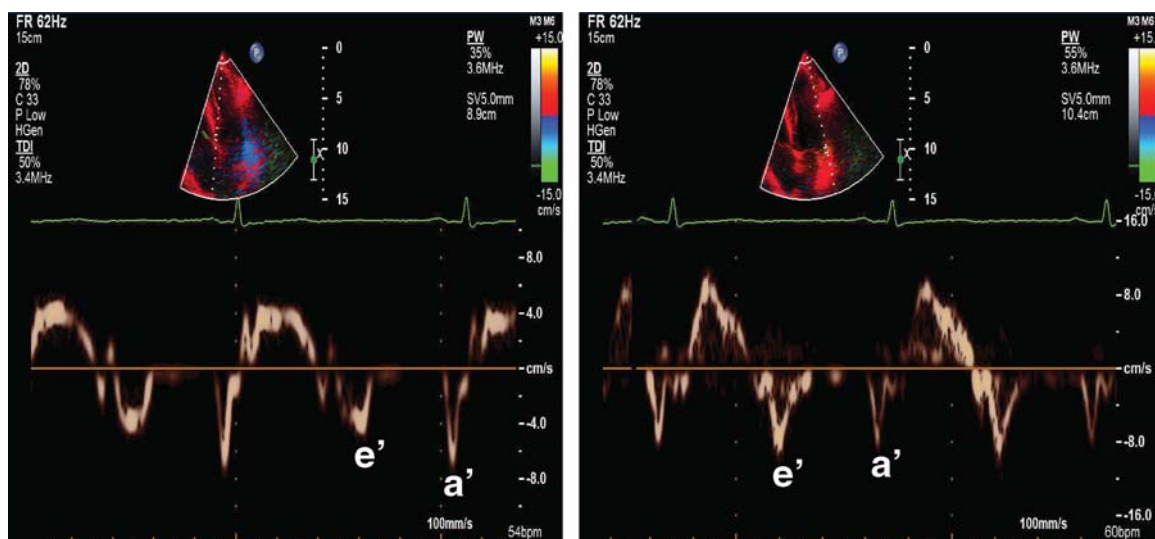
Septal (*left*) and lateral (*right*) tissue Doppler recordings from a patient with an anteroseptal myocardial infarction. Notice the difference between septal $\dot{\epsilon}$ (5 cm/s) and lateral $\dot{\epsilon}$ (10 cm/s). It is imperative to use the average of septal and lateral $\dot{\epsilon}$ velocities in such patients to arrive at more reliable assessments of LV relaxation and filling pressures.
